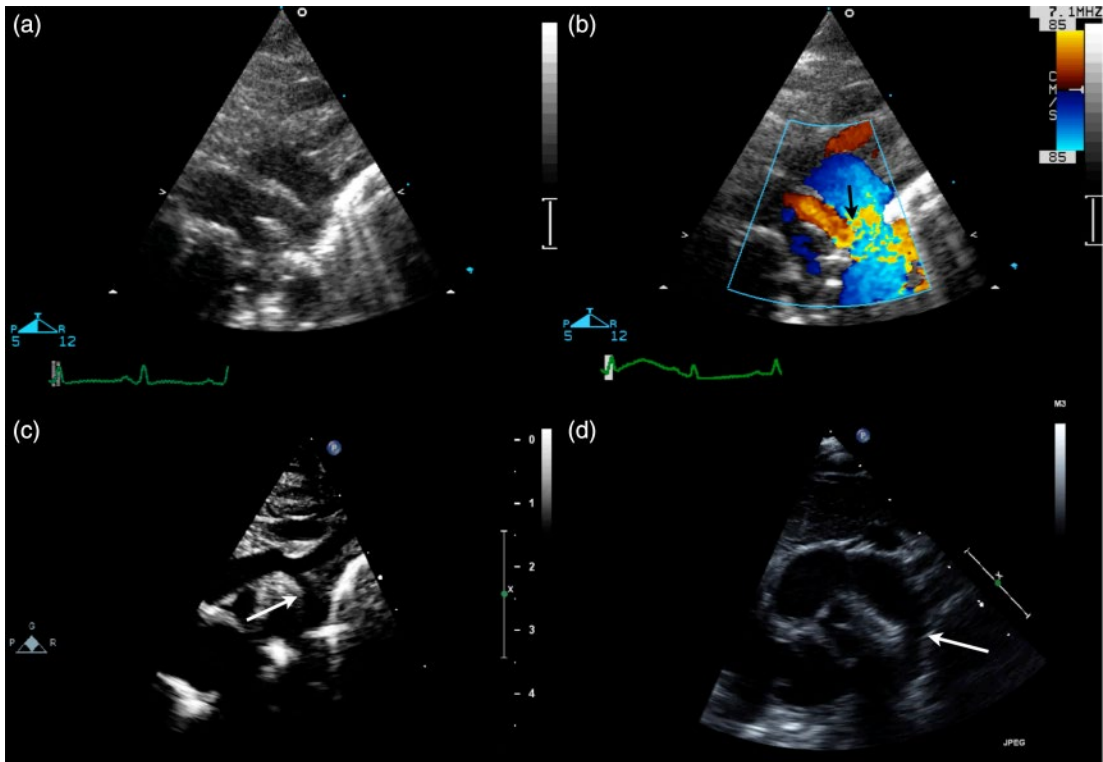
Supra-sternal window for viewing the aortic arch, possible coarctation and/or patent ductus arteriosus (PDA). PDA demonstrated by two-dimensional ultrasound (a) and Doppler ultrasound (b). PDA (arrow); (c, d) Aortic coarctation (arrows) with arch hypoplasia.
